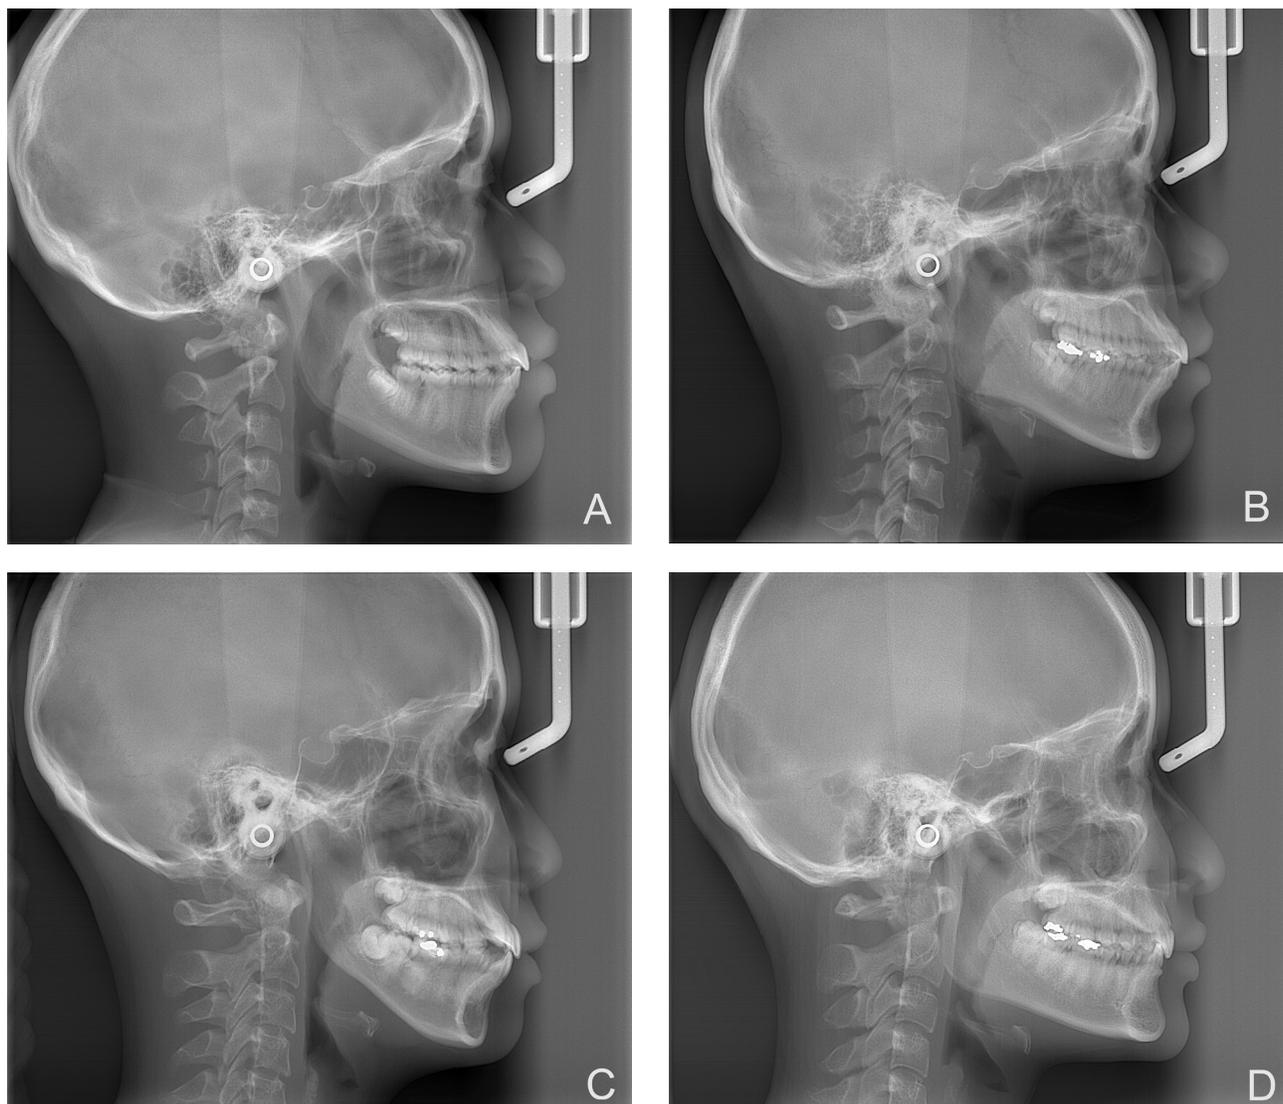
Examples of lateral cephalometric radiographs show A, normal upper posterior dental height (N-UPD); B, normodivergent/short upper posterior dental height (Normo/S-UPD); C, hyperdivergent/short upper posterior dental height (Hyper/S-UPD); D, and hypodivergent/short upper posterior dental height (Hypo/S-UPD)
